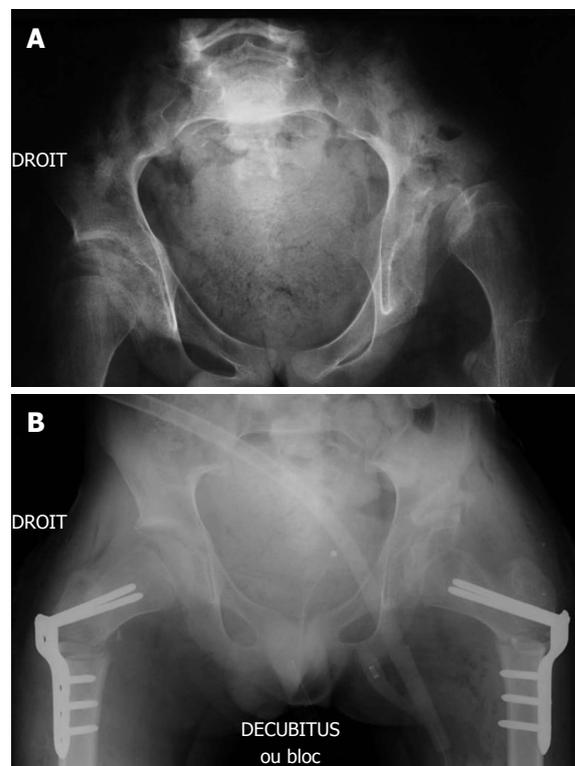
Pre (A) and post-operative operative antero-posterior (B) radiographs of the pelvis (male patient, closed triradiate cartilage).
